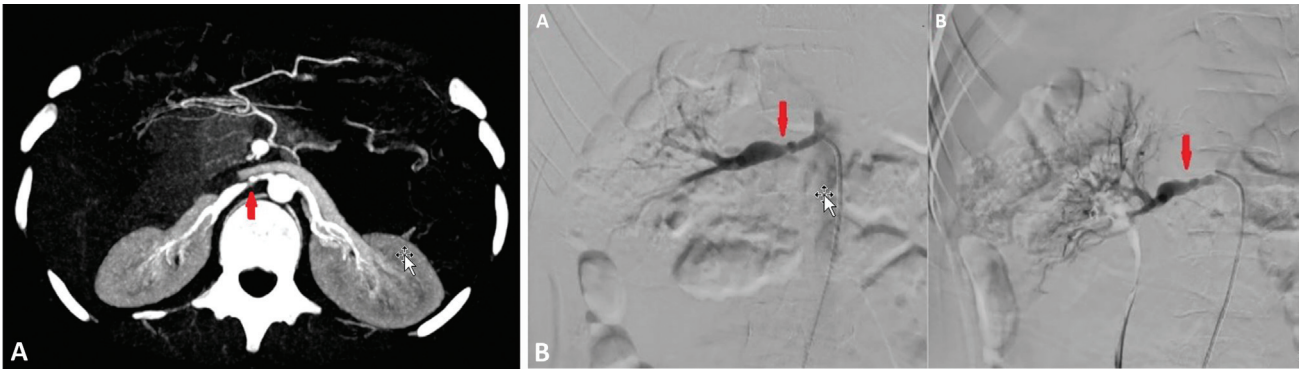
(A) Maximum intensity projection image of computed tomography angiography in an adolescent boy presenting with hypertension, demonstrating stenosis of proximal segment of right renal artery (red arrow) with poststenotic dilatation due to fibromuscular dysplasia. (B) Fibromuscular dysplasia: a. Renal angiogram showing beaded appearance of proximal right renal artery (red arrow in a). b. Postpercutaneous angioplasty image showing reduction in stenosis (red arrow in b).
